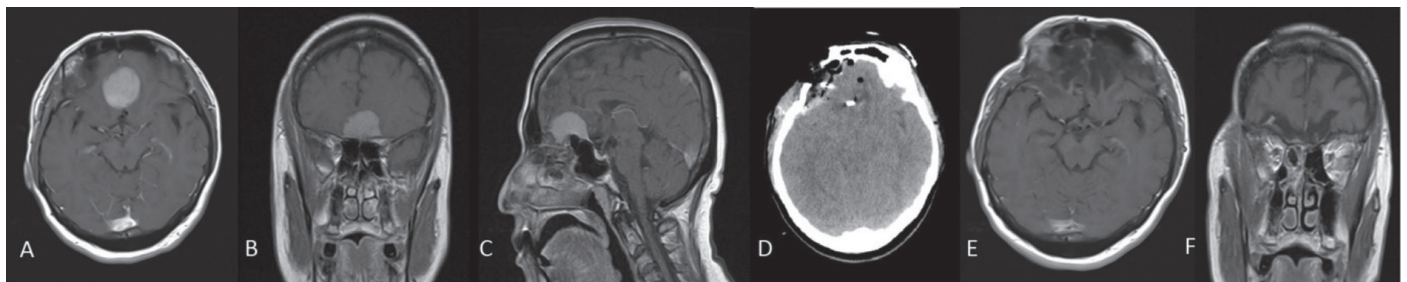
Preoperative T1W cranial magnetic resonance imaging (MRI) axial (A), coronal (B), sagittal (C) showing homogenous contrast 35x30 mm extraaxial sphenoid wing meningioma. Postoperative 1. day brain computed tomography (D) showing total resection of the tumor. T1W MRI axial (E), coronal (F) on the second year of operation, no recurrent tumor detected
